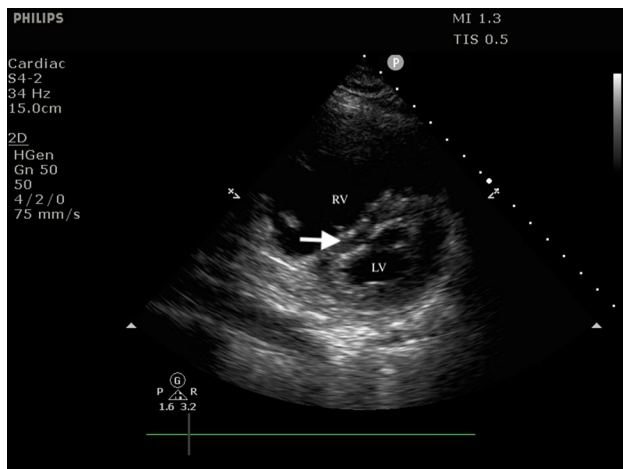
Transthoracic parasternal short-axis view showing a dilated right ventricle (RV) with a D-shaped septum (white arrow), and a small underfilled left ventricle (LV)
